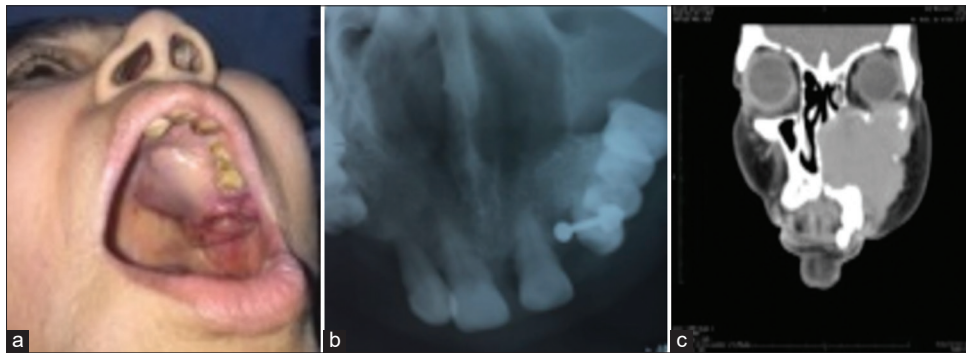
(a) Intra-oral picture showing swelling extending from left central incisor to hard palate not crossing midline, (b) Occlusal before extraction showed destructive lesion, (c) Section of contrast-enhanced computed tomography scan showing extent of swelling (Case 3)
